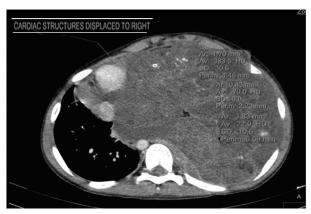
CT scan images massive tumor occupying the left hemithorax and whole mediastinum, Heart displaced into right hemithorax, tracheal displacement and compression, left diaphragm flattened and displaced into abdomen.
